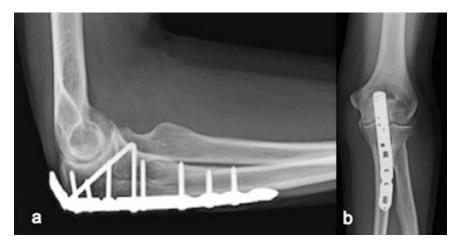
At 6-month follow-up (a) lateral and (b) anterior-posterior plain radiographs demonstrated a healed fracture, reduced radiocapitellar joint, intact hardware, and no evidence of HO. © Andrew Green, MD
